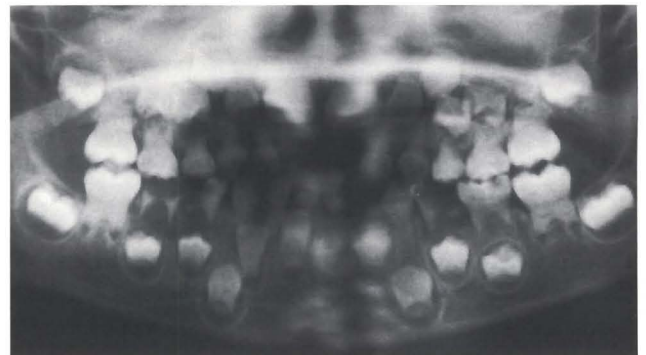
Dental orthopantomograph of the first case, note obliterated pulp chambers and linear pulp appearance on molar teeth.
